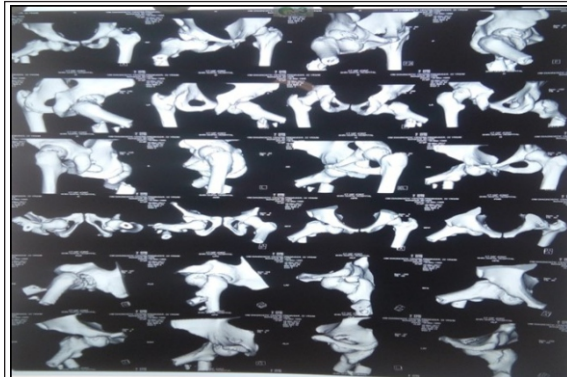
Preoperative 3D-CT scan of pelvis and proximal femur.
